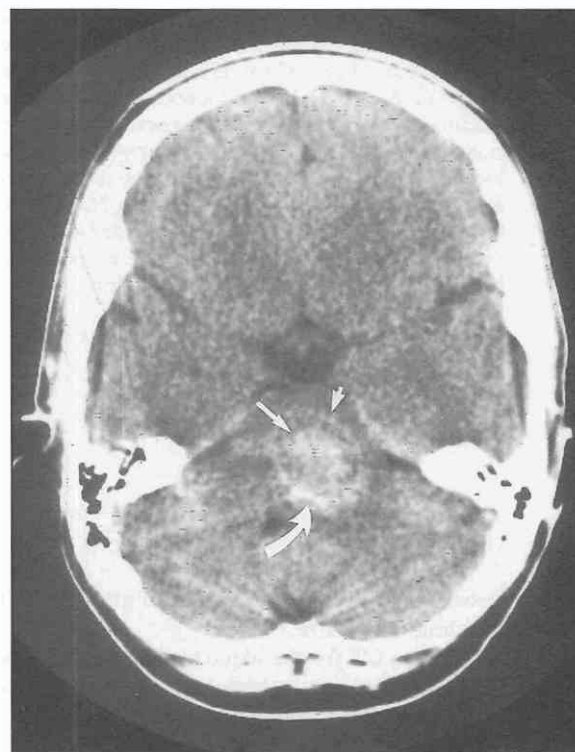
CT examination without contrast of a pontine cavernous angioma demonstrating focal calcification (curved arrow) and peripheral (short arrow) and central (long arrow) hemorrhagic degradation products.
